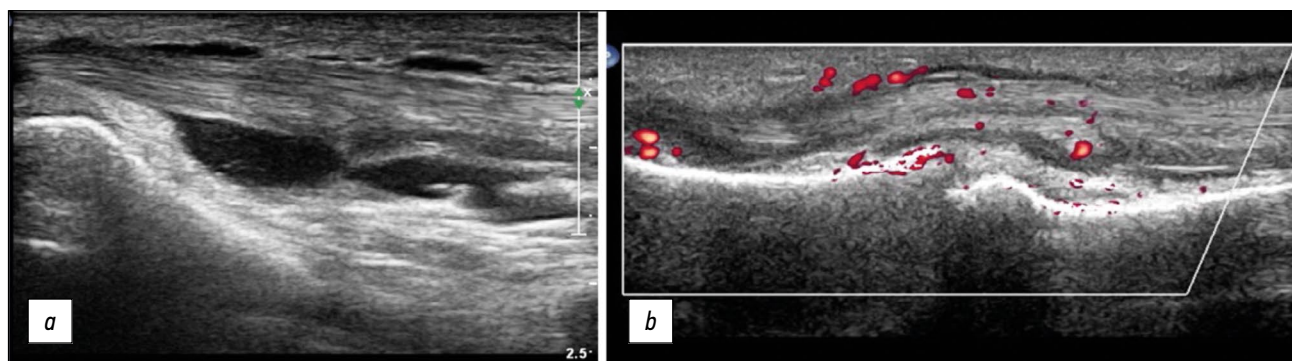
Longitudinal sonogram of tenosynovitis of the tendons of the long flexors of the second finger of the foot (*a*) and the flexor tendons of the third finger of the hand (*b*). Signs of tenosynovitis on ultrasound are similar in both cases and are characterized by thickening of the tendon, fluid in the synovial membrane, and hypertrophy of the synovial wall of the tendon sheath. Using the color Doppler imaging mode, blood flow in the synovium is observed.
